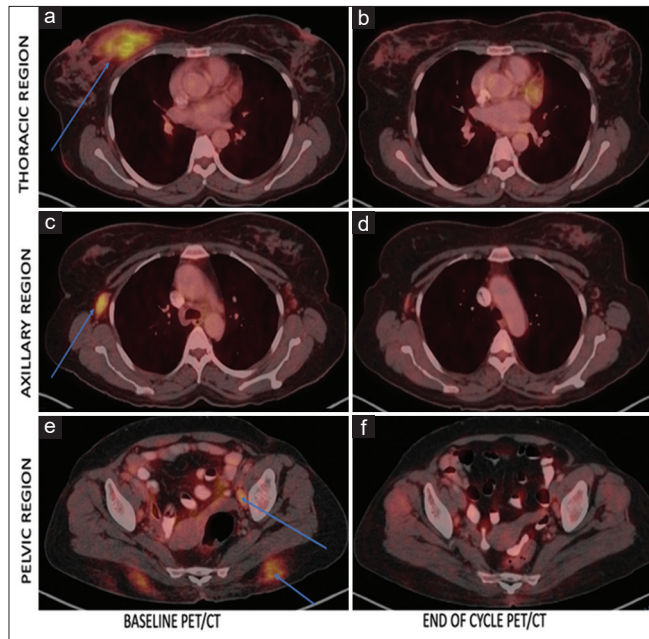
(a-f) Fused axial images of breast lesion, axillary, and pelvic lymph node in the baseline and end of treatment positron emission tomography/computed tomography, respectively
